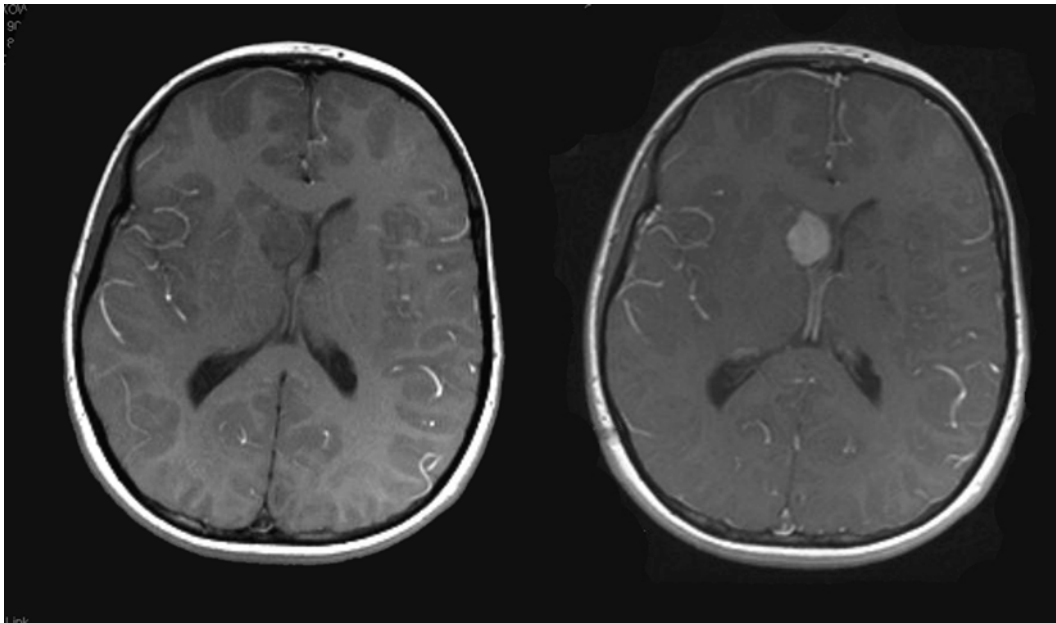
Pre- and postgadolinium T1-weighted axial MRI, 9-year-old with TSC1 mutation. A SEGA is seen on the right, dense contrast enhancement is seen.
